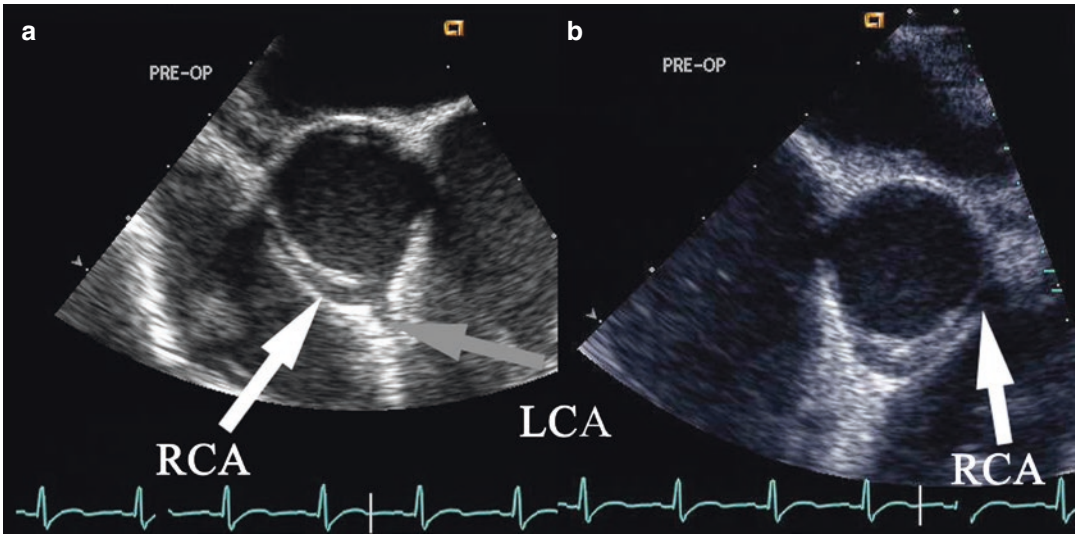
Transesophageal echocardiography at the mid-esophageal aortic short axis view (a) abnormal left coronary artery (LCA) from right aortic sinus (ALCA-R) grey
